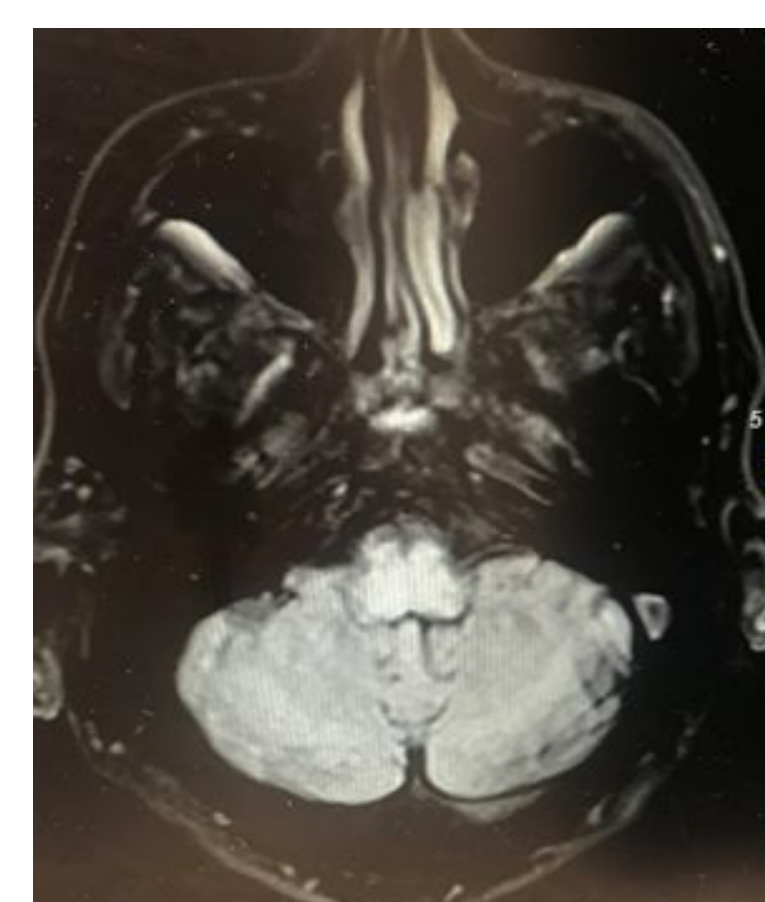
Axial MRI FLAIR image, redemonstrating the hyperintensity seen in Image 1A.
